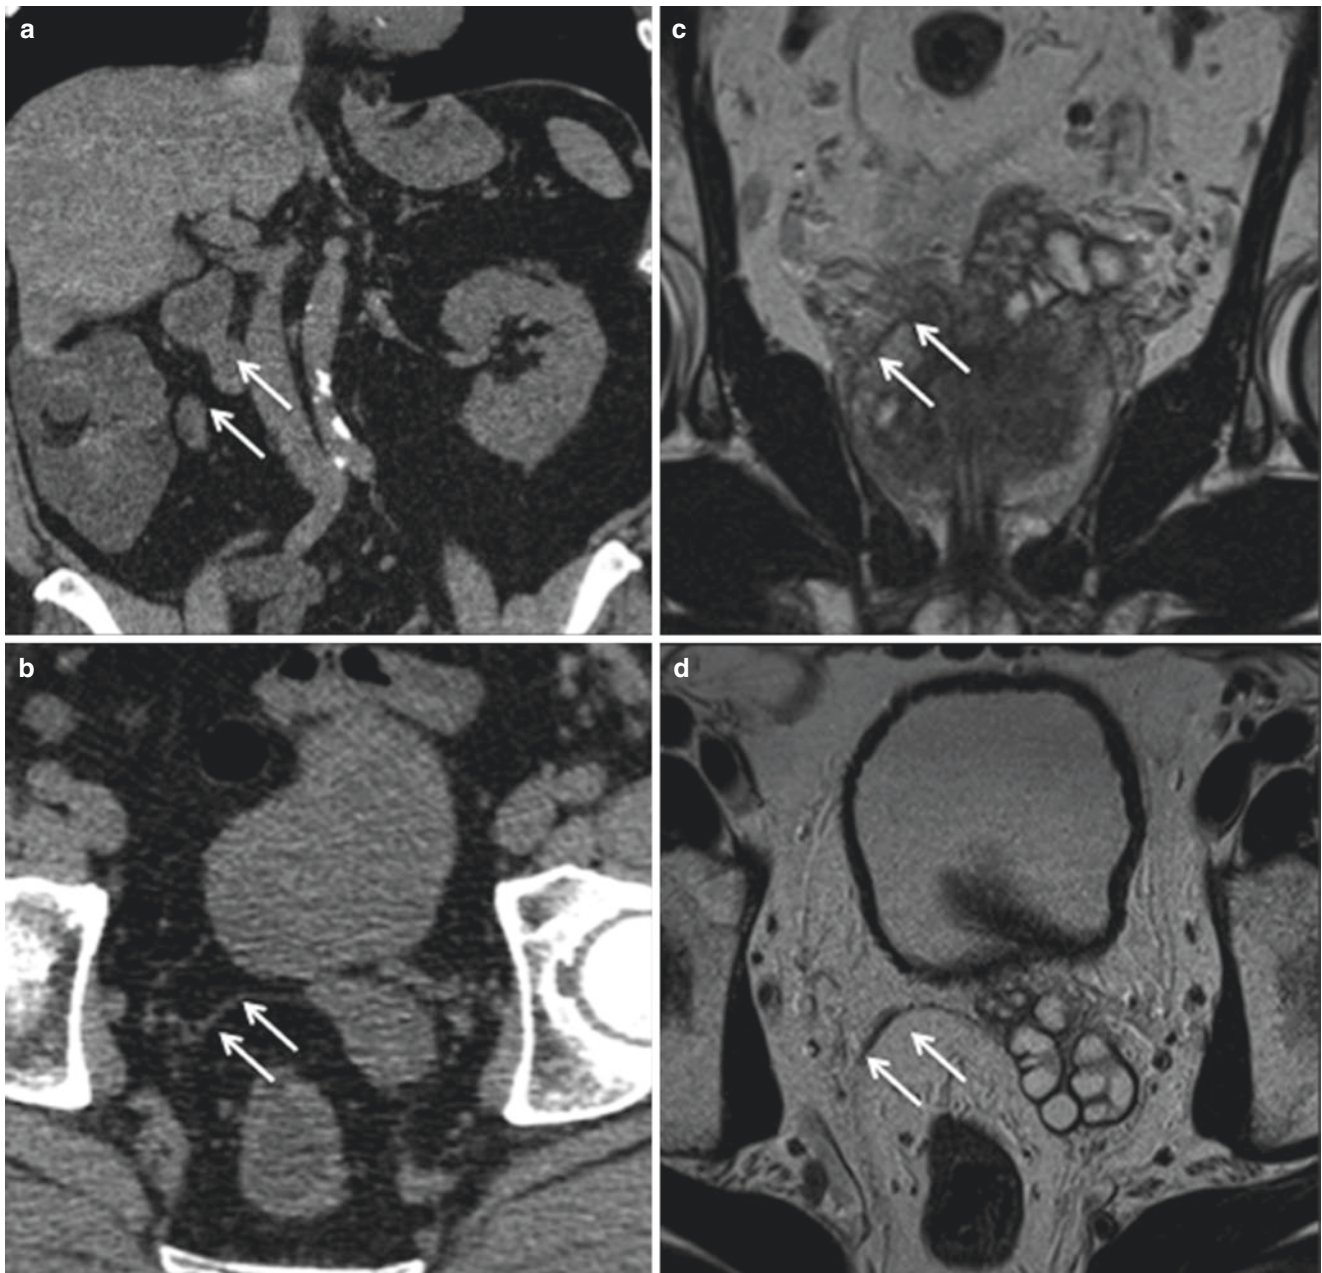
Agnesis of the SV and of the kidney in a 30-year-old man with infertility. CT image shows right renal agnesis (a) and absence of the SV (b) ipsilateral (arrows). Coronal (c) and axial (d) T2-weighted MR image shows again
